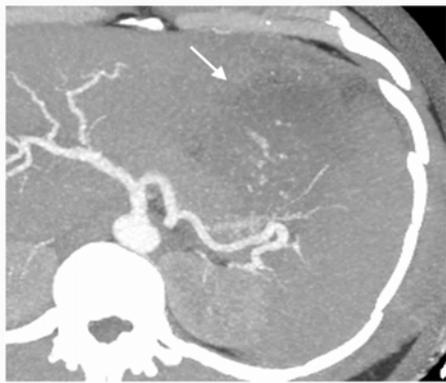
Contrast enhanced CT demonstrating a splenic infarct.
